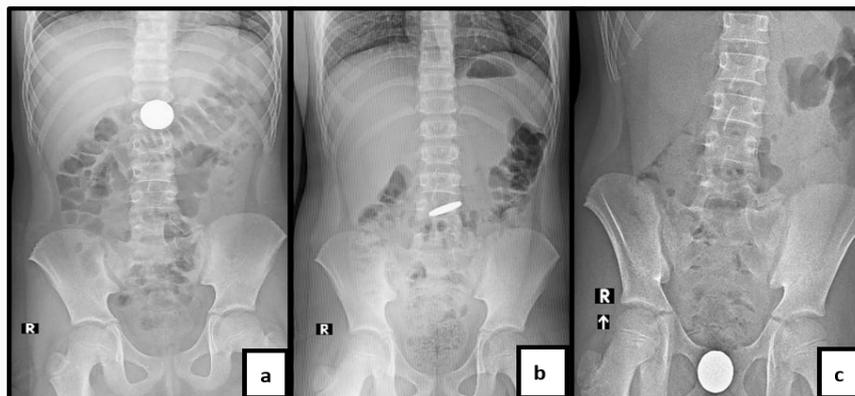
(a) X-ray 1st and 3rd day (b) day 6th (c) day 7th repeated X-ray.
